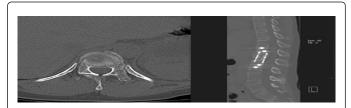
An axial A). and a sagittal view B). of the CT scans demonstrated a fracture of T11 vertebra with loss of about 15% of the height and minimal involvement of the spinal canal.
